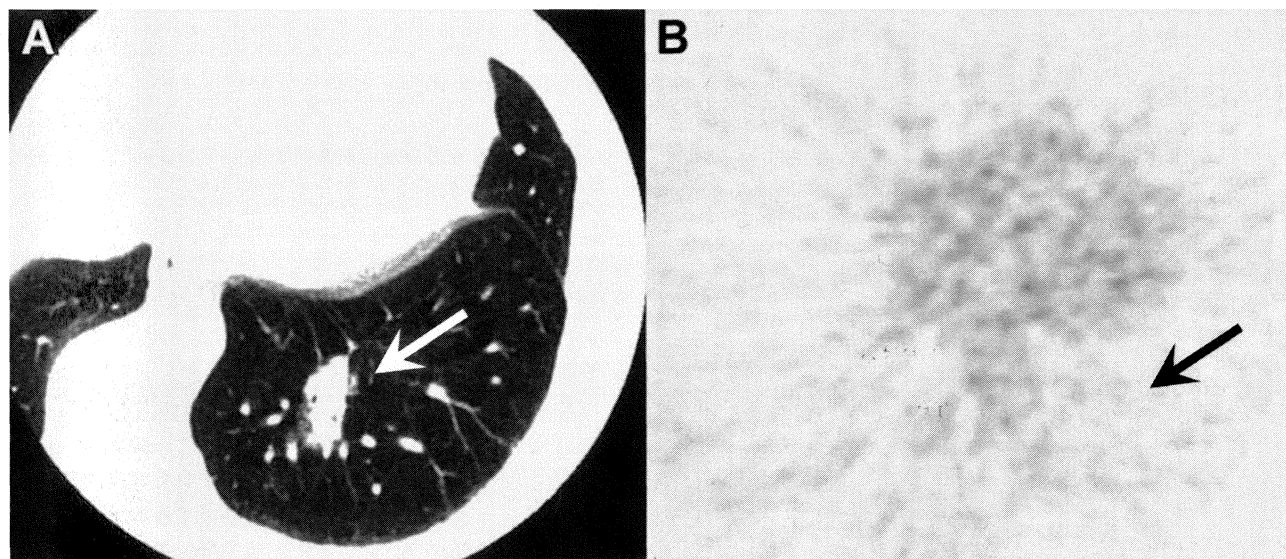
HRCT上solid patternでFDG低集積度を呈した肺腺癌症例
